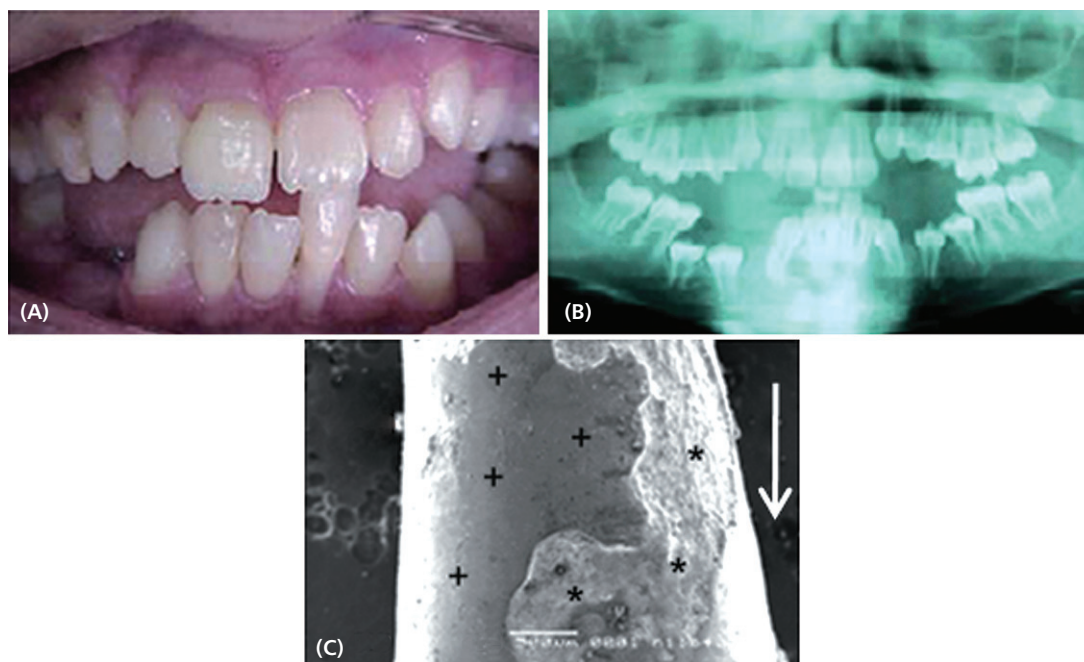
At 14 years of age, patient A experienced spontaneous exfoliation of the permanent mandibular central incisor (tooth 31) during brushing. The clinical photograph (A) and corresponding panoramic radiograph (B) were taken prior to tooth exfoliation and show effects of odonto-HPP on the permanent dentition, including delayed eruption of several permanent teeth (e.g., mandibular left and right premolars 34, 35, 44, and 45), enlarged pulp chambers, and thin dentin. The SEM imaging of the apical root region of the central left incisor (tooth 31) shows the lack of cementum and exposed dentin surface with no indication of attached collagenous PDL fibers (+), as well as evidence of root dentin resorption (stars). Arrow indicates the occlusal direction.
